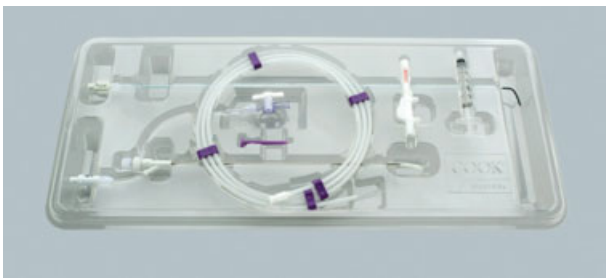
Three components packaged together as the Radiographic Tubal Assessment Kit, or Fluoroset (Cook Medical).
